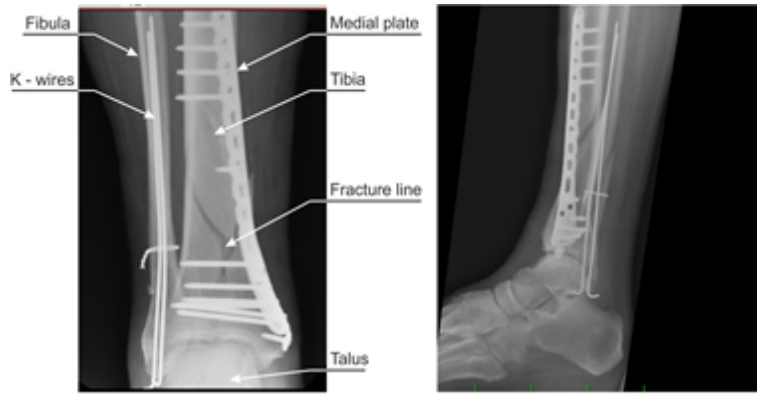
X-ray snapshots after fixation with plate.
